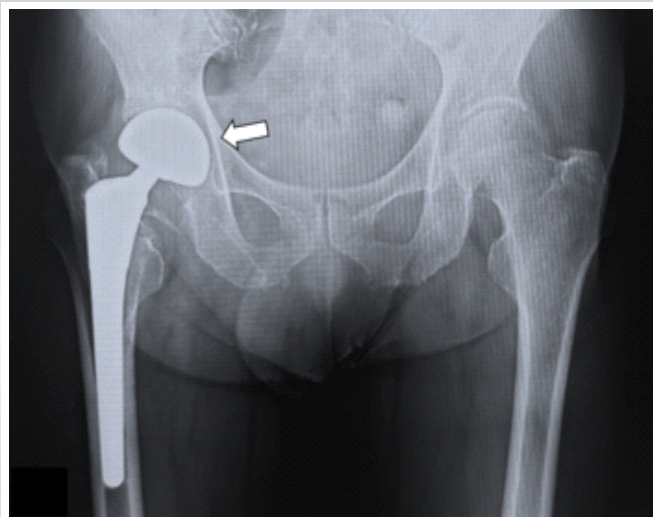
Radiograph in year X-3. Very mild femoral head migration is observed (white arrow).
